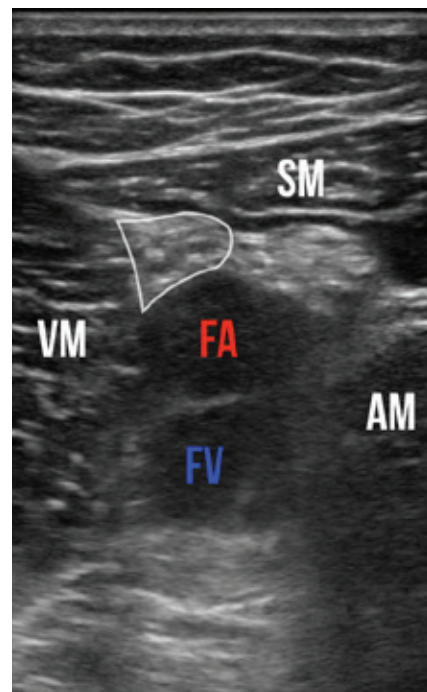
Transverse sonographic view of the adductor canal. The sartorius muscle (SM) forms the “roof.” Vastus medialis (VM) is medial, and the adductor magnus (AM) is lateral. The saphenous nerve (white outline) lies between the femoral artery (FA) and the sartorius. FV is the femoral vein.
